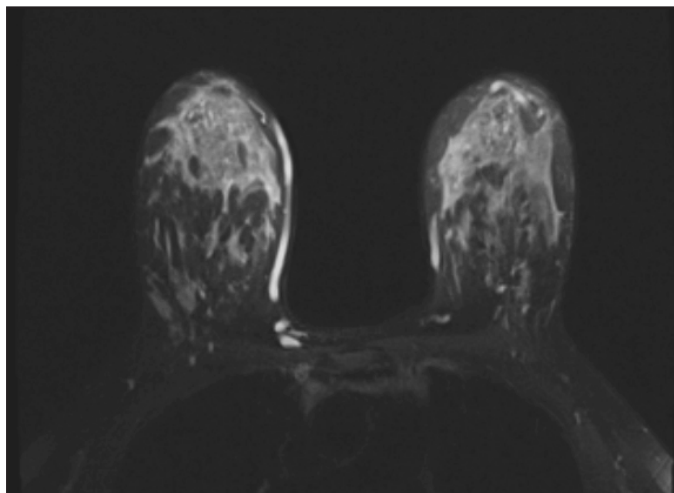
T2-weighted image shows no corresponding hyperintense signal at the site of the focus in the left breast at 11 o'clock anterior depth.
